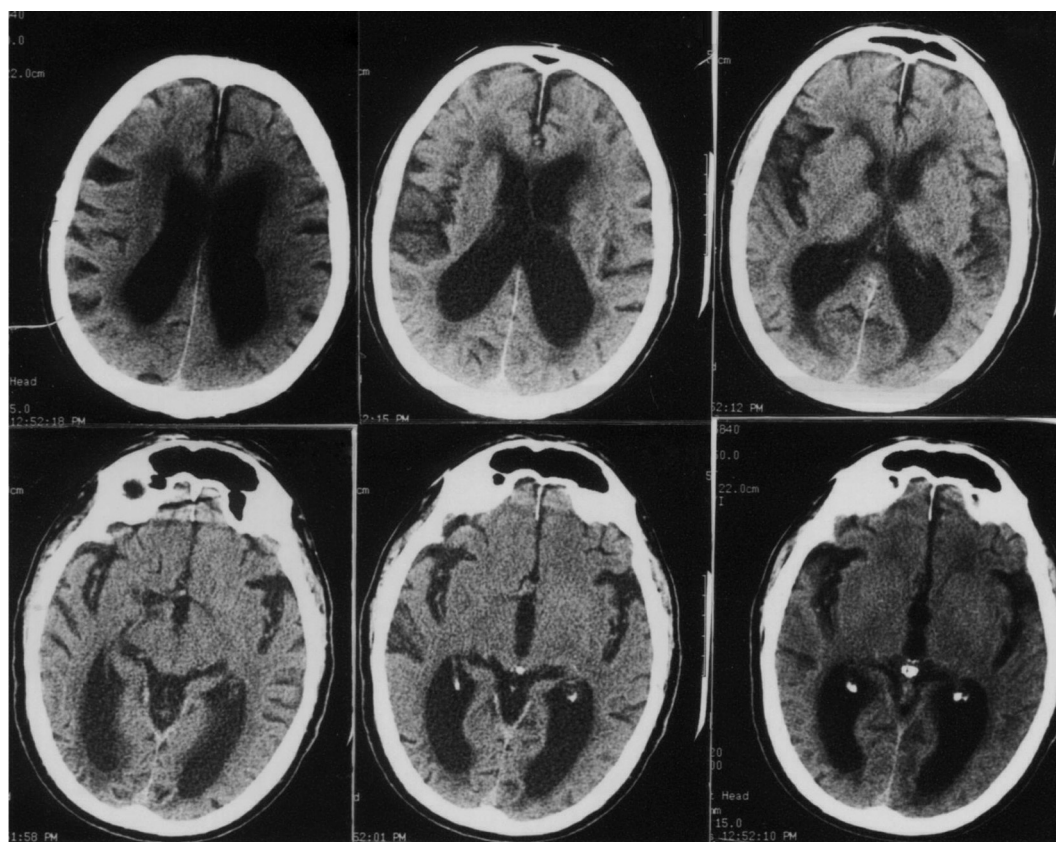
Computed tomography (CT) scan showing bilateral symmetrical striking enlargement of the posterior horns of the lateral ventricles with prominent sulci in the parietal and occipital regions and widening of the sylvian fissures bilaterally.
